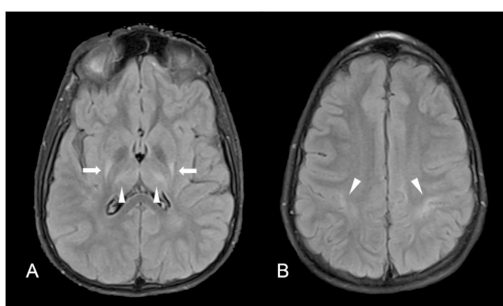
Axial FLAIR images of a 14 year old male, showing an example of the most common involvement observed, including ventral posterior lateral thalamus (A, arrowheads) and frontal perirolandic cortex (B, arrowheads). In this subject also putamina are involved (arrows).
